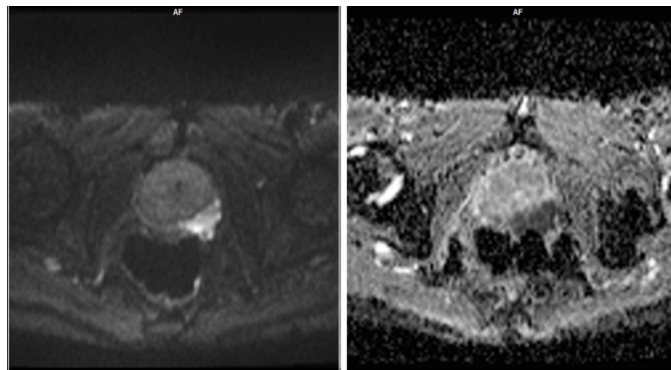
Lesion in left peripheral zone is showing restricted diffusion on DWI
